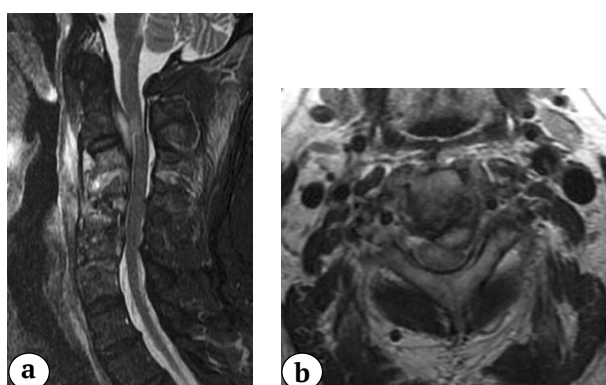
MRI after the second operation: a – STIR images; b – T2 images: prevertebral, epidural abscesses, C3–C5 spondylitis, focal myelopathy at C2–C3
